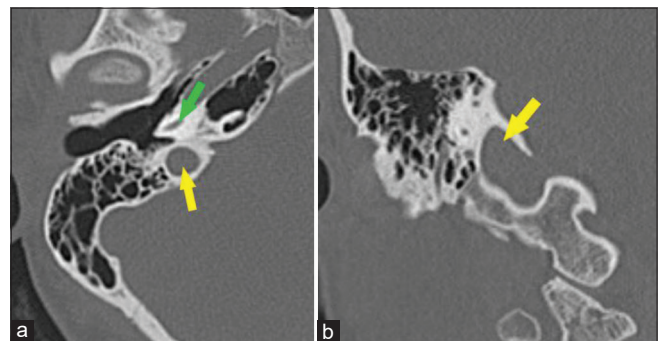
(a) Axial CT image of the temporal bone, high riding jugular bulb(HJB) is seen. (yellow arrow: jugular bulb, green arrow: cochlear basal turn). (b) Coronal CT image of HJB (yellow arrow: jugular bulb)
